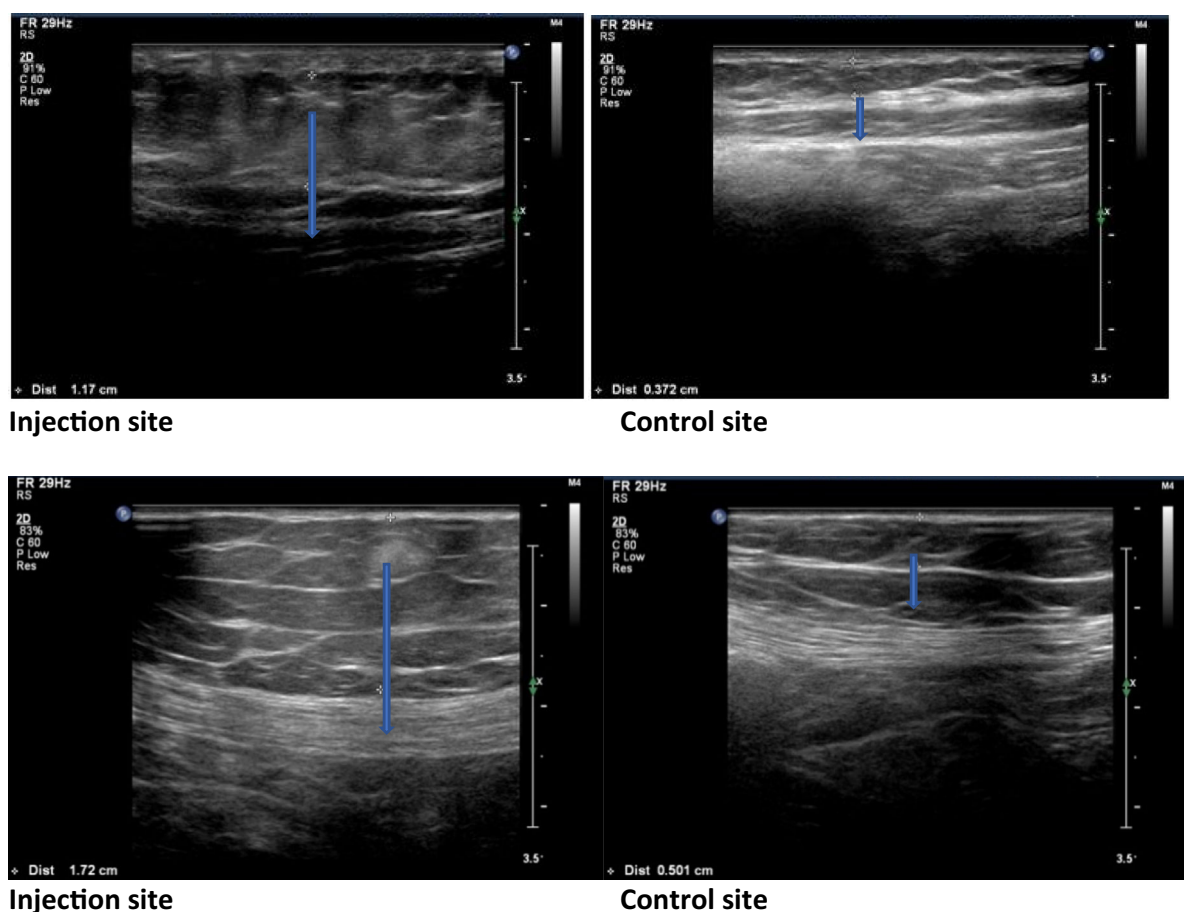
Increased subcutaneous tissue thickness and heterogeneous echo texture at injection site compared to control site on ultrasonographic examination in two patients with lipohypertrophy
